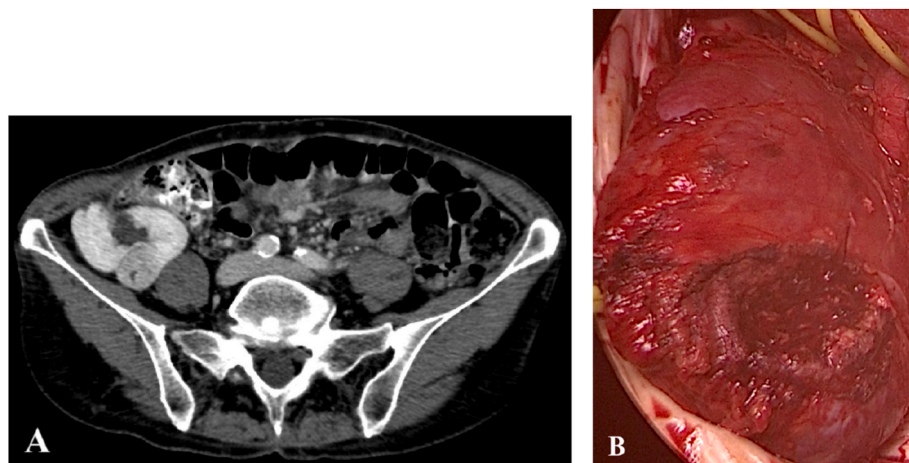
CT scan showing a 22 mm local recurrence in the autotransplanted kidney (A); open enucleation of the recurrence in the autotransplanted kidney (B).
